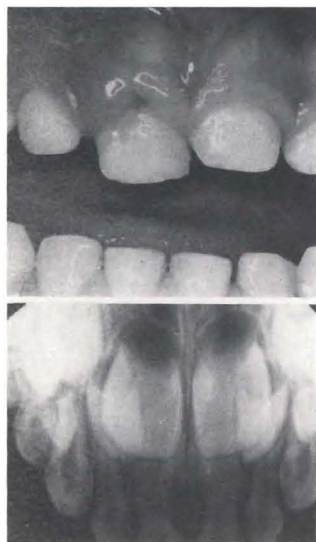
Clinical observations: J.W., 4.5-year-old girl struck tooth E on sidewalk. Tooth E was lingually displaced, mobile, normal color, sensitive to percussion and palpation, with swollen labial gingiva (Clinical photo). Oblique mid-root fracture seen in radiograph. The tooth was extracted seven days after trauma.
